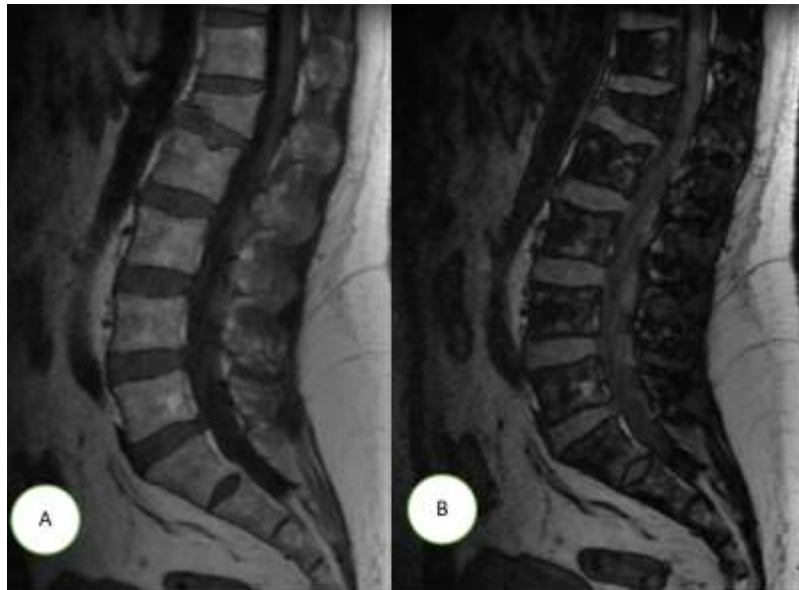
Sagittal MRI of the lumbosacral spine of a 71-year-old man. A) IP Dixon image shows partial loss of height of DV1 with anterior wedging B) OP image shows a reduction of marrow SI owing to its high fat content. % drop = 79% consistent with benign osteoporotic fracture).
